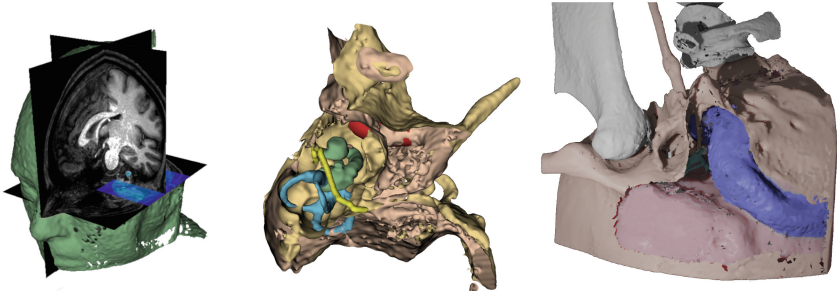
Left (3DSlicer): 3D model of the head combining a full-head MRI and a CT. Center (3D Slicer) and right (Blender): 3D combined model after a virtual mastoidectomy.
